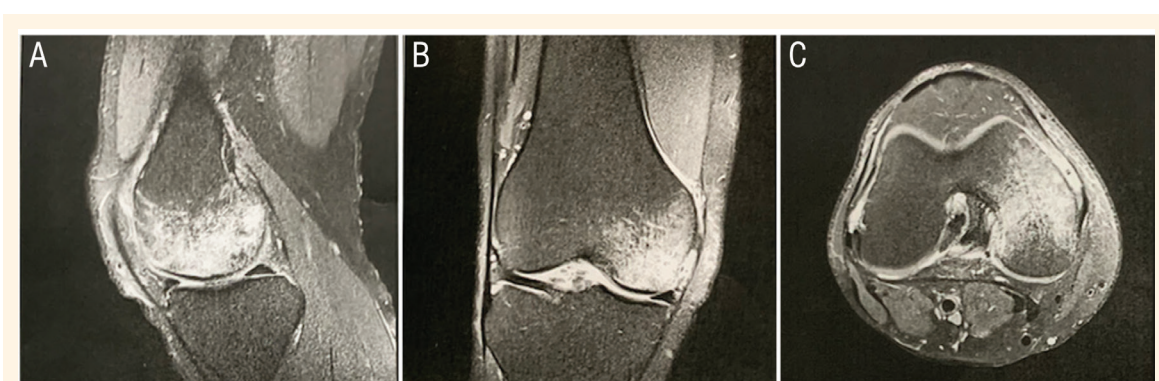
Magnetic resonance imaging of the right knee showing extensive osteonecrosis in (A) sagittal, (B) coronal and (C) transverse views. The bone marrow edema was located in the medial femoral condyle.
